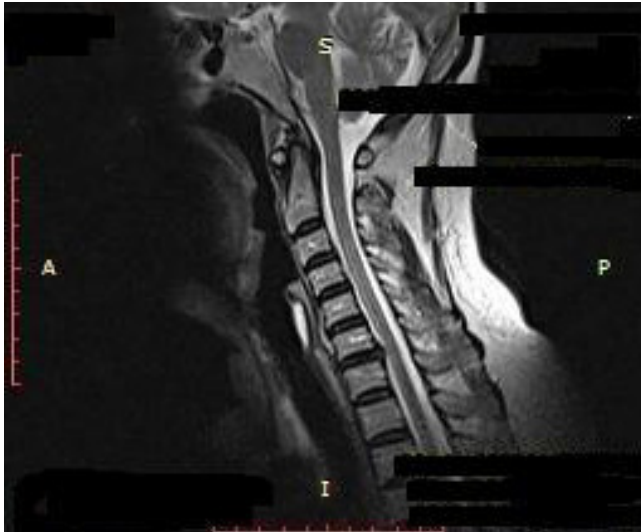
Sagittal T2-weighted image of the initial magnetic resonance imaging study reveals a large disc herniation at the C6-C7 disc space.
